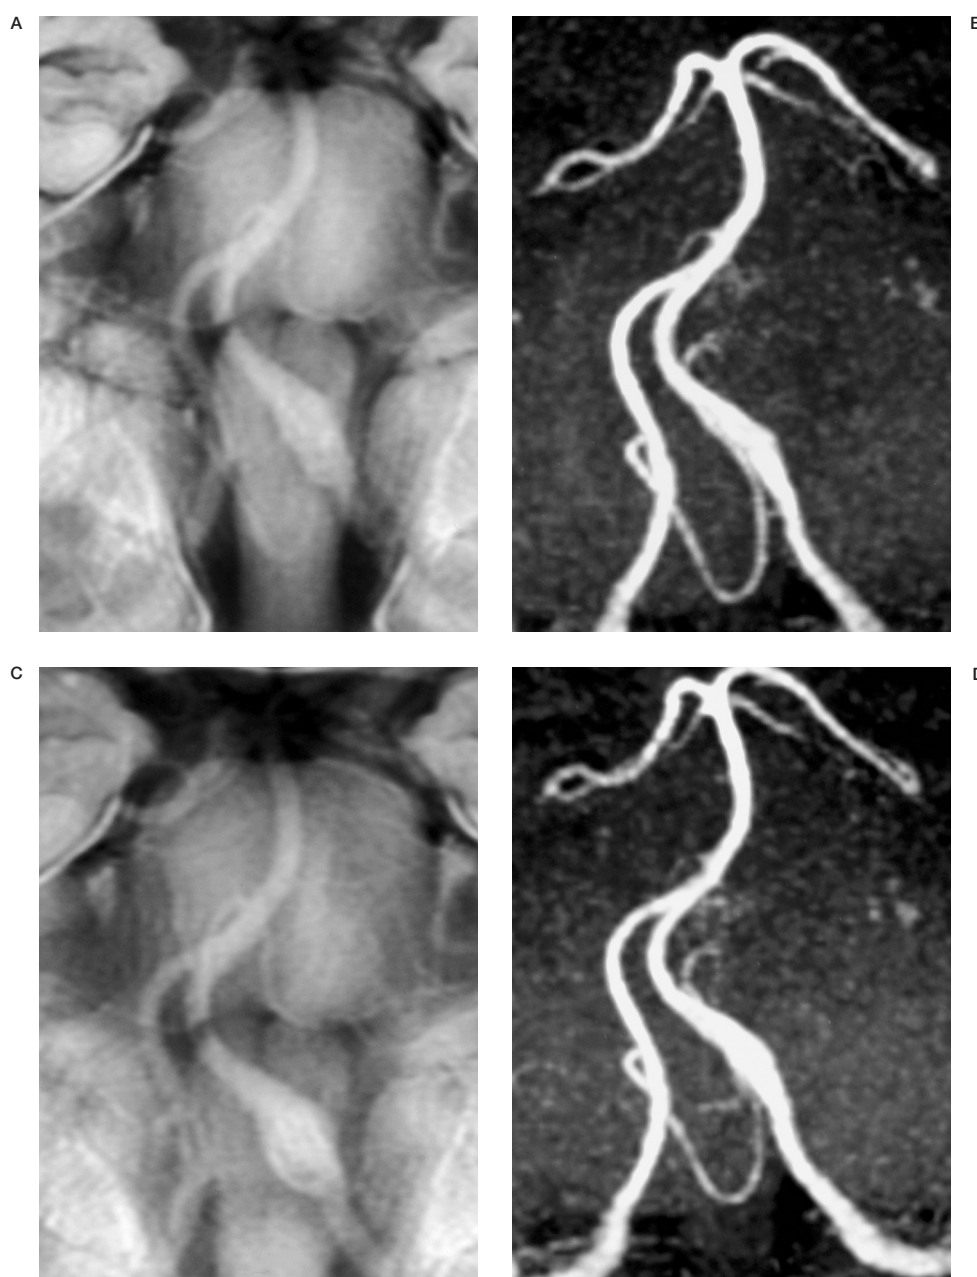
Case 1: 52-year-old male patient with left VA dissection. BPAS-MRI (A) and MRA (B) shows fusiform dilatation of the left VA at two months after onset. Ten months after the initial symptom, the patient complained of headache again. At that time BPAS-MRI (C) reveals enlarging fusiform appearance though the MRA (D) shows no remarkable change compared with prior study.
